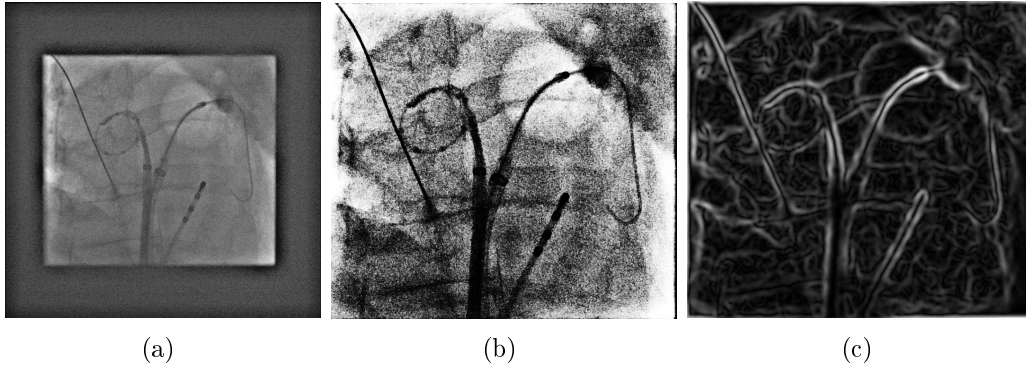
Original X-ray image showing the cryoballoon (a), image after removing the area under the shutters and histogram equalization (b), gradient magnitude image obtained by applying the first derivative of a Gaussian (c).
